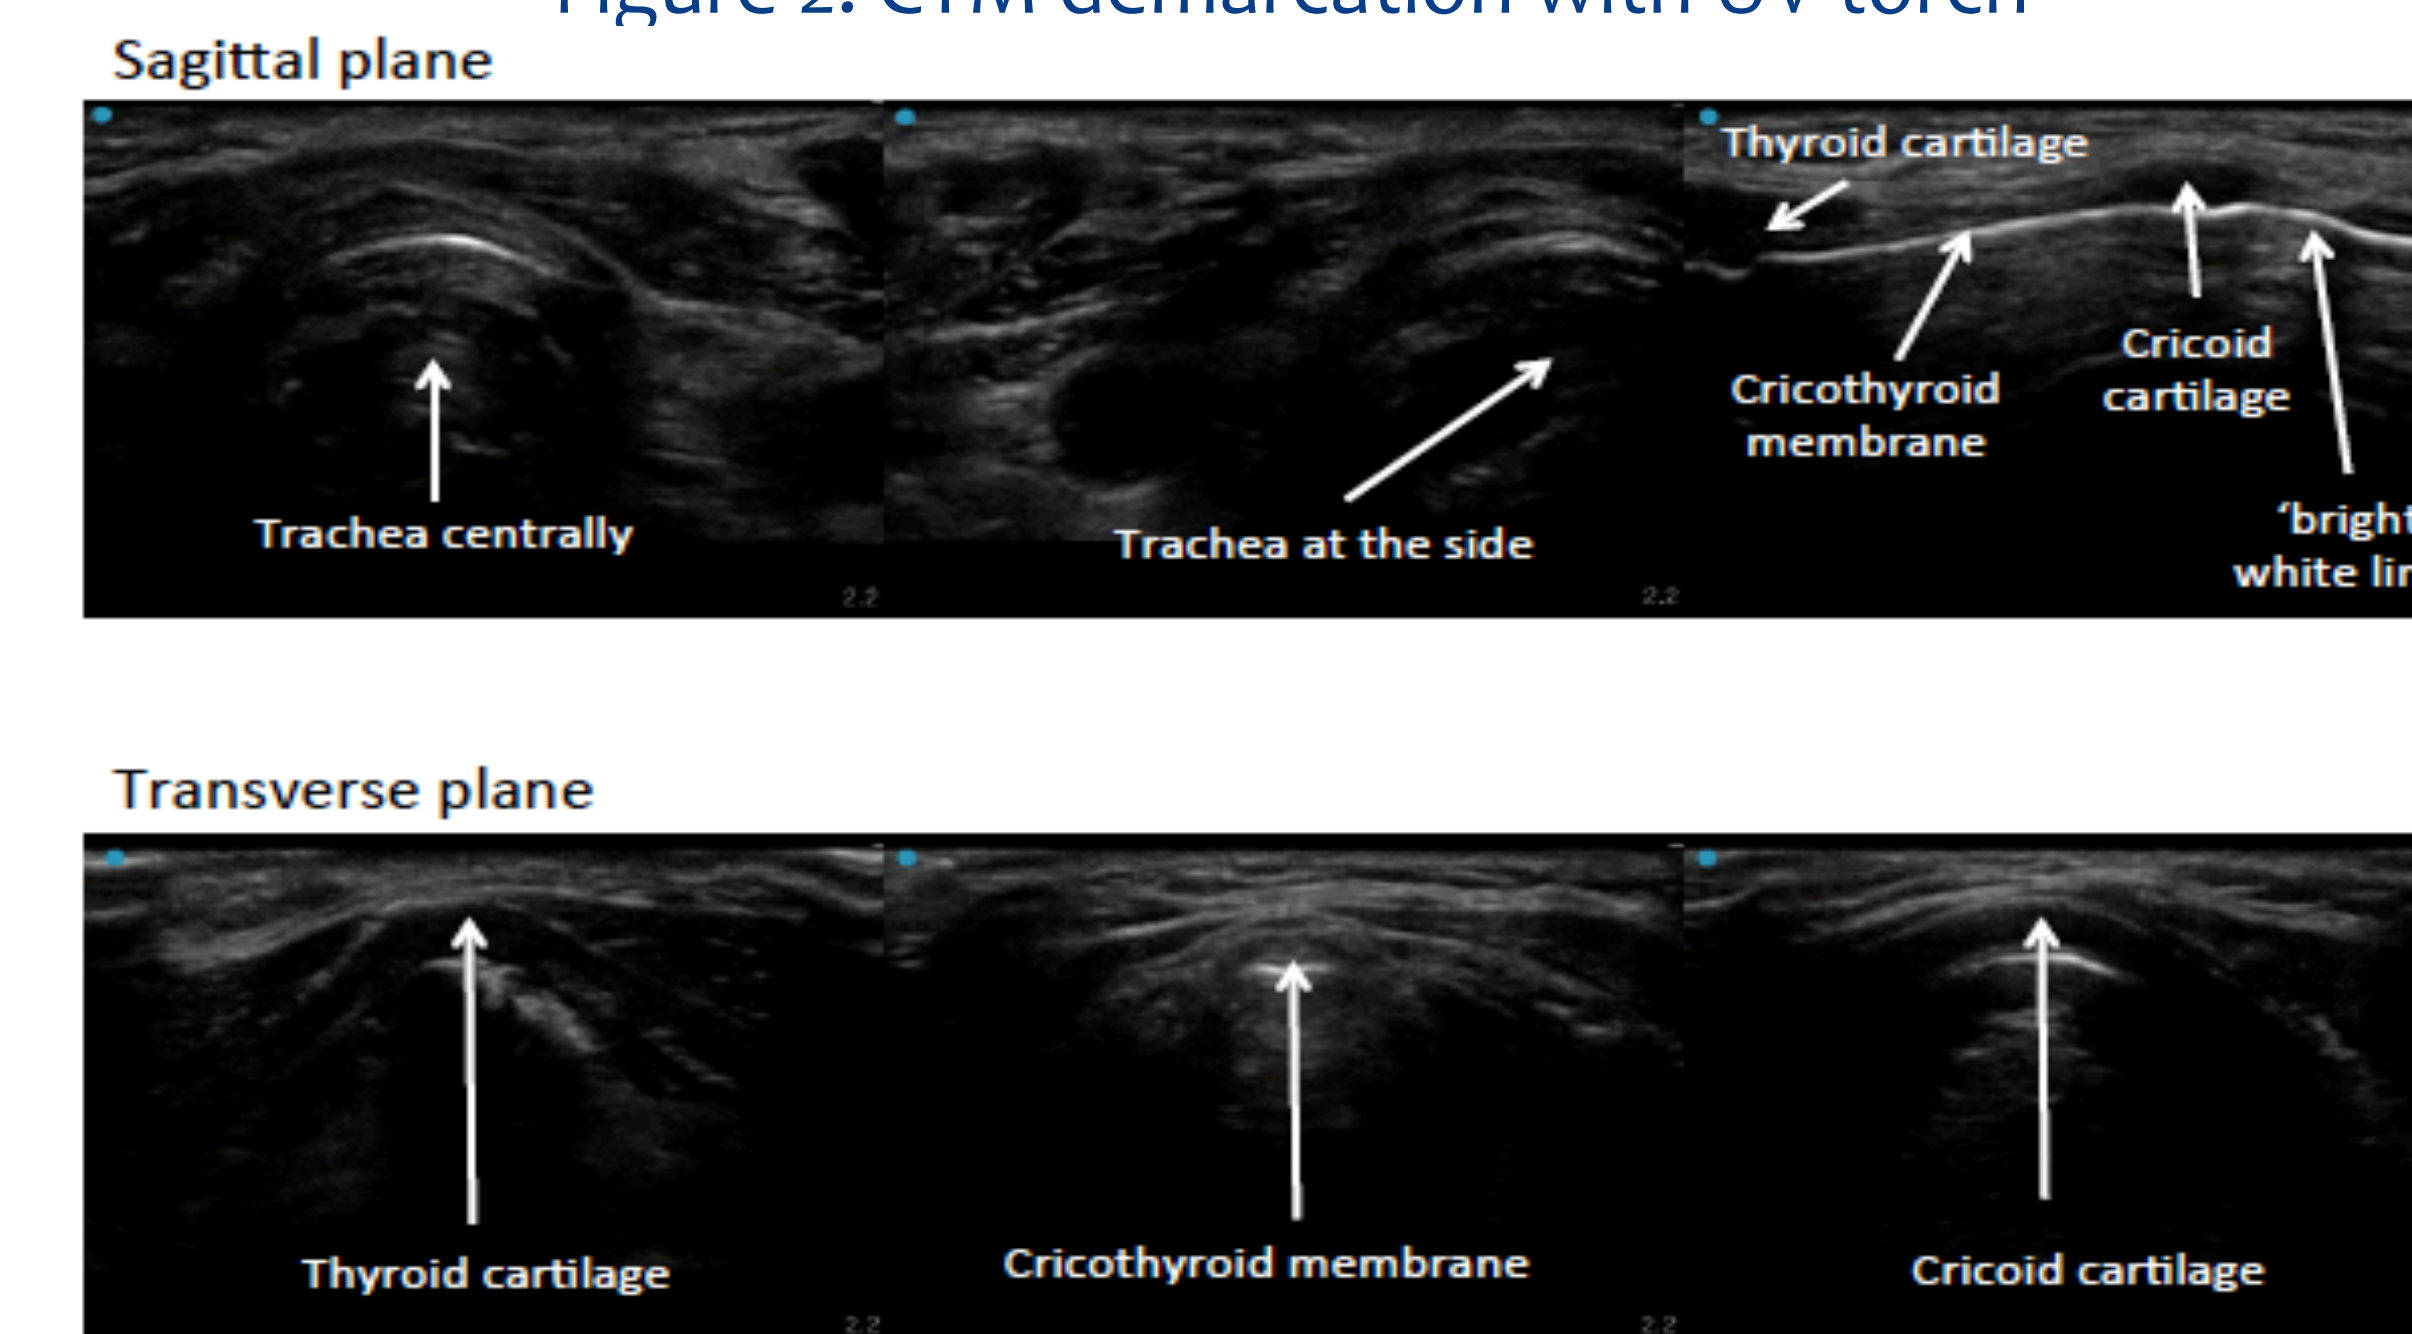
Ultrasound images of Subject A
